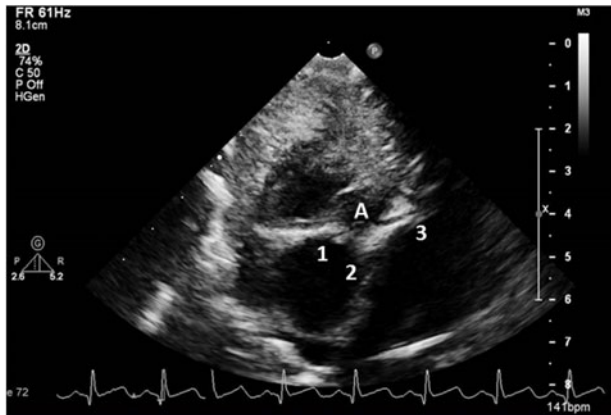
Parasternal short axis view of three coronary vessels originating from the main pulmonary artery. A: Main pulmonary artery; 1: right coronary artery; 2: circumflex artery; 3: left anterior descending artery.
